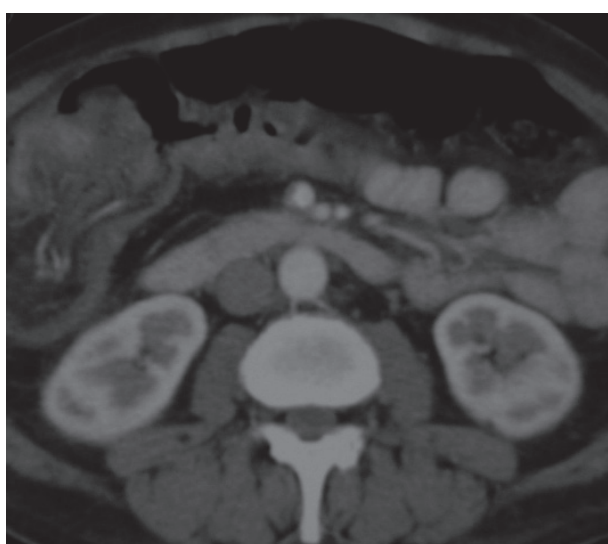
Enhanced CT scan through mid-abdomen (parallel to the axis of the intussusception) showing elongated mass in the right abdomen with central low density mesenteric fat containing enhanced mesenteric vessels. Colocolic intussusception, which was due to colon cancer and confirmed at surgery (Case no. 13).
